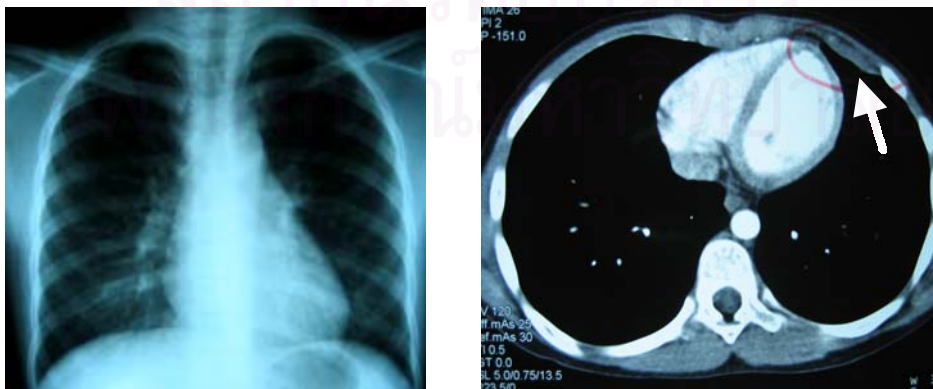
3B. Chest roentgenogram (3A) performed at one week after treatment showed dramatic decrease of left pleural effusion. Computed tomography of the chest (3B) performed at 3 months after treatment showed marked decrease of left pleural effusion with residual pleural masses (Arrow).
